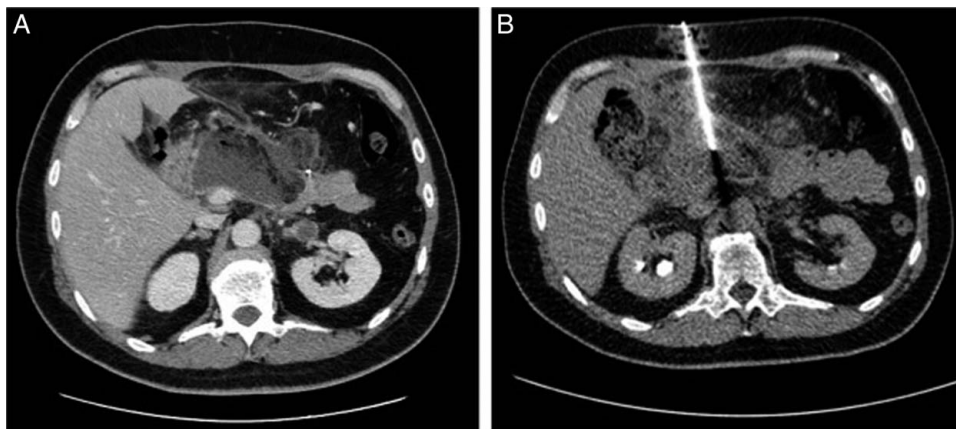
(A) CT-scan shows postpancreaticoduodenectomy fluid collection. (B) A percutaneous drainage is inserted into the collection using the Seldinger technique under CT-scan.
